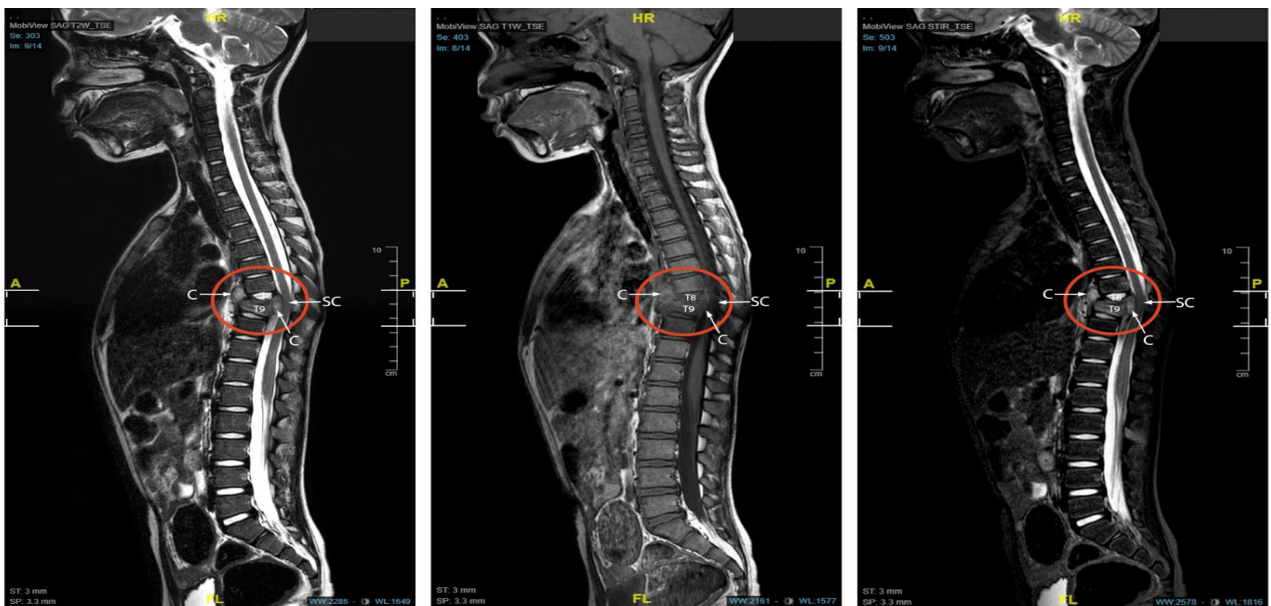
MRI of the whole spine reveals total destruction of T8 vertebral body with loss of vertebral height causing gibbus deformity, and reduction of T9 vertebral body height with superior endplate erosion, with intervertebral disc space of T8/T9 narrowed. Anterior and posterior subligamentous collection seen (labelled as C), with posterior collection seen compressing the spinal cord (labelled as SC) resulting in spinal canal stenosis.
